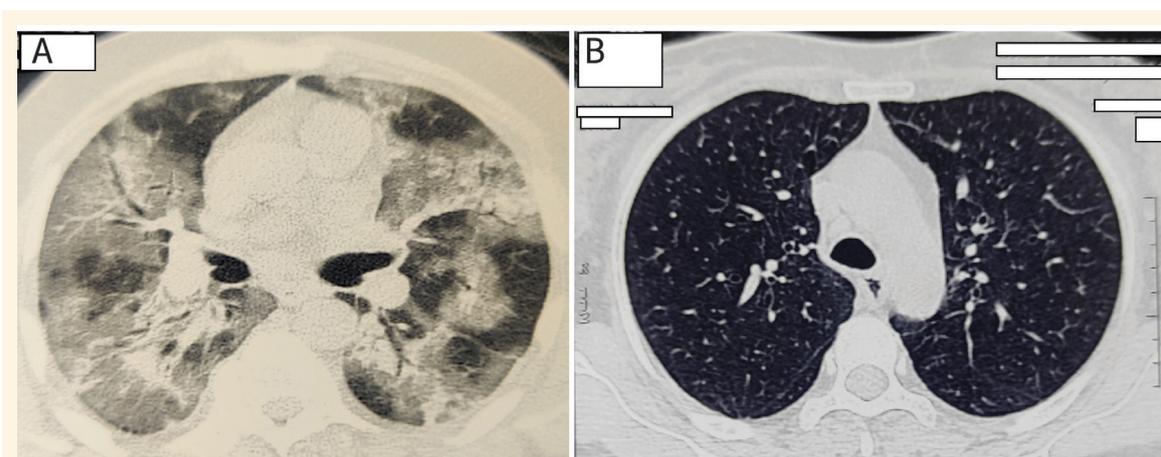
Chest computed tomography scan showing (A) the presence of ill-defined reticulonodular infiltrates in both lungs and (B) complete resolution after four weeks.
